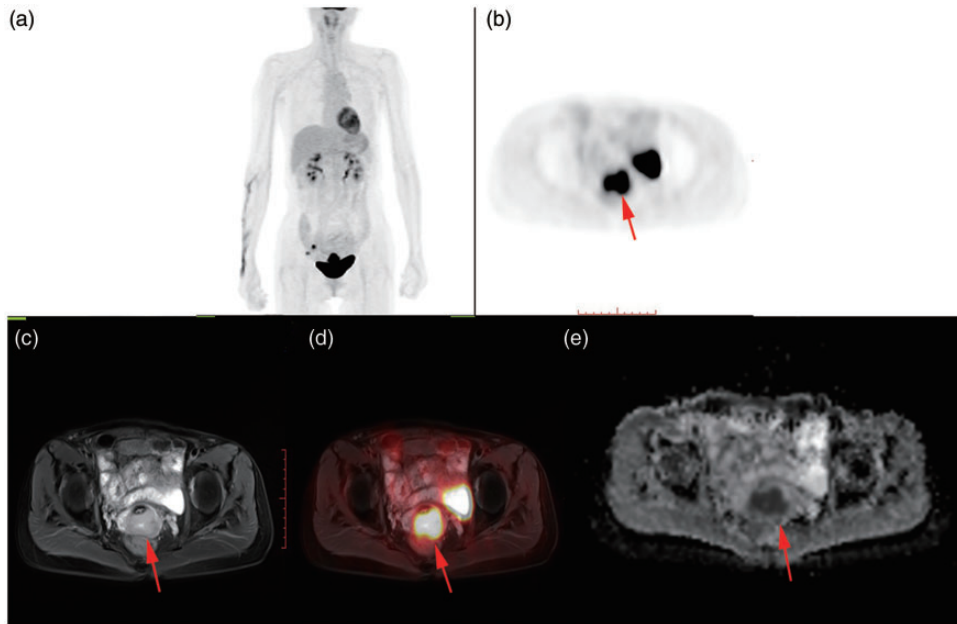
Imaging findings in a 26-year-old patient with FIGO IBI cervical cancer. (a) Whole-body  $^{18}\text{F}$ -FDG uptake. (b) Tumor and uterine cervix  $^{18}\text{F}$ -FDG uptake map. (c) Tumor CT map. (d) Fused  $^{18}\text{F}$ -FDG PET/CT image of tumor lesion map.
